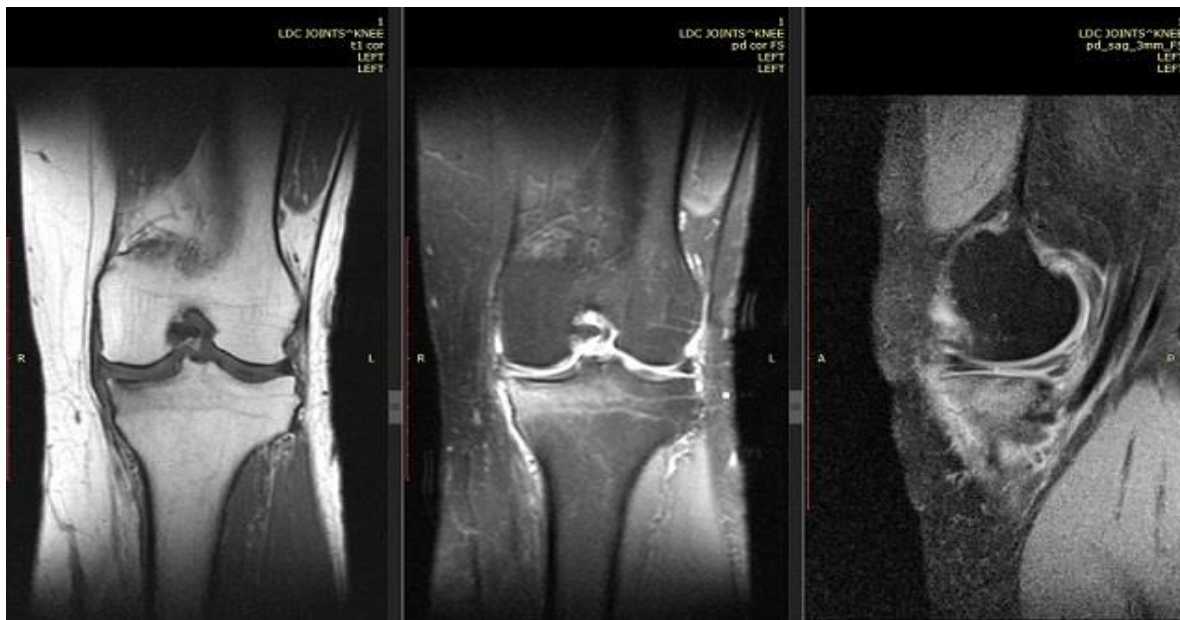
Pretreatment MRI.
